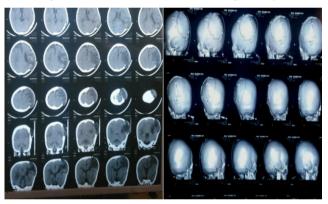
Preoperative CT brain showing growing skull fracture and post-operative ct brain showing repair of the defect by bone cement and mini plates
